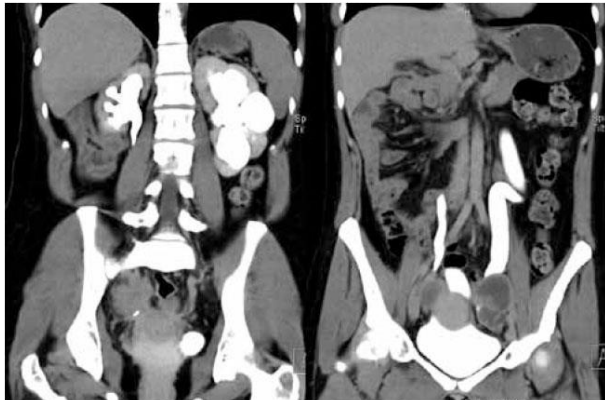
Image of bilateral hydronephrosis and hydroureter associated with asymptomatic DIE, on a CT scan with contrast. A 26-year-old patient with a 3-year history of infertility, showing no other symptoms. On the transvaginal ultrasound, bilateral ovarian endometriomas and a bilateral hydro-ureteronephrosis were found. The patient underwent CT, scintigraphy, had ureteral stents placed and was qualified for surgical excision of endometriosis.
